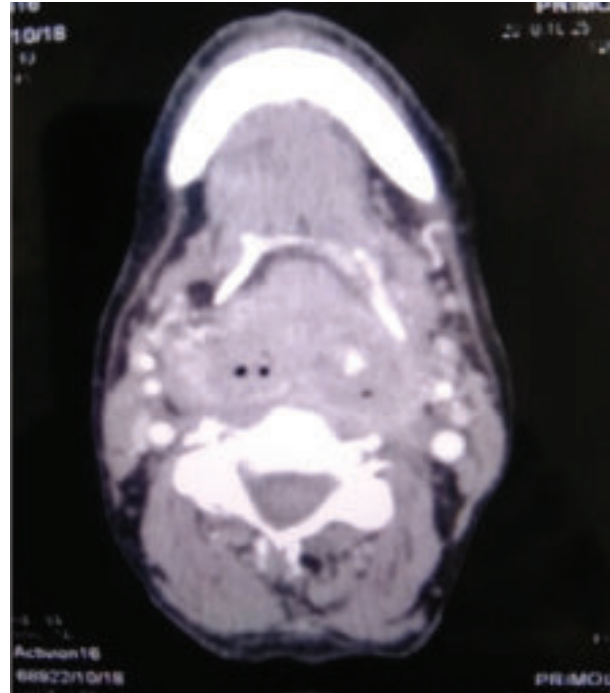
Axial post-contrast CT scan of neck showing large mixed density mass at glottic and supraglottic part of larynx.
